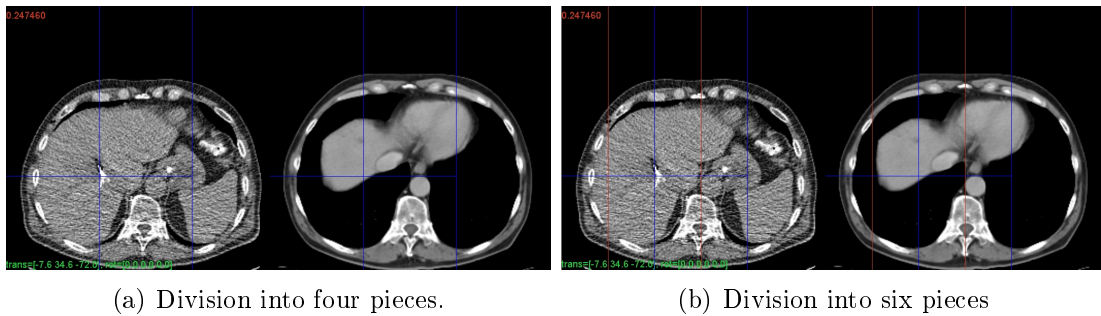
Piecewise division on clinical images. (a) and (b) show each time on the left the CT-fluoro slice and on the right the initial pose position in the volume. The blue lines divide the liver into four not-overlapping pieces, while the red lines include two overlapping parts. The lines which are drawn in the CT-volume slice are only just for orientation, the registration process searches all the volume.
